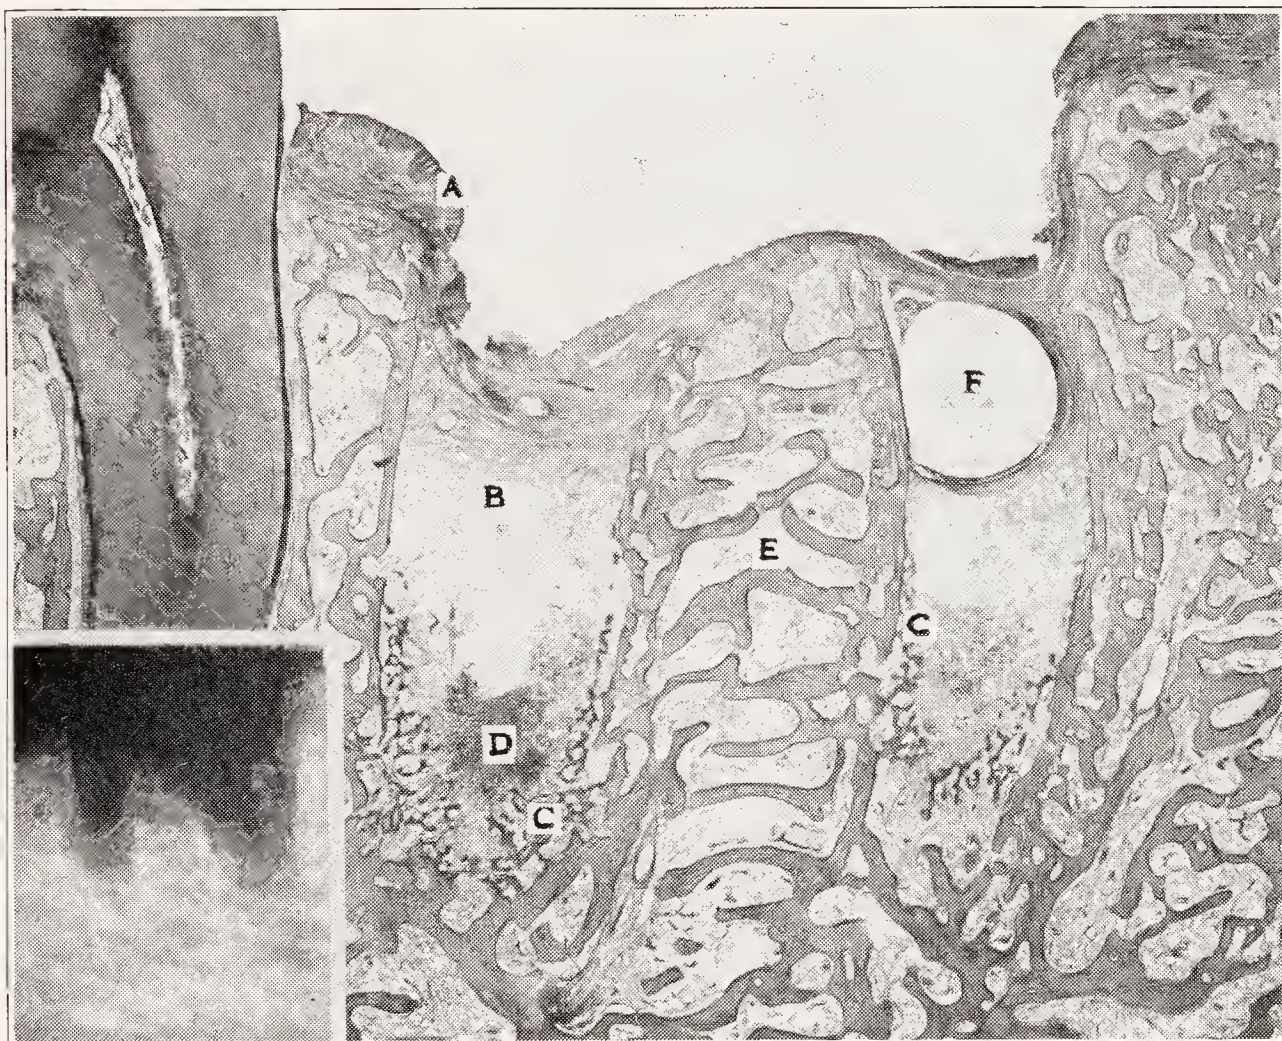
Extraction wound, six weeks old, of a lower second molar in man. *A* epithelium; *B*, scar tissue; *C*, new bone in fundus; *D*, remnants of original blood clot; *E*, horizontal spicules of interradicular bone; *F*, abscess cavity. Insert: Radiograph of extraction wound. (Claffin, Jour. Am. Dent. Assn.)
